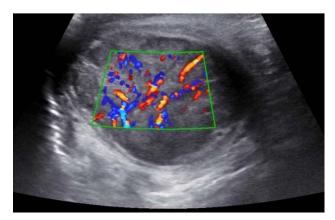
Colour Doppler showing moderate-high vascularity within the mas
